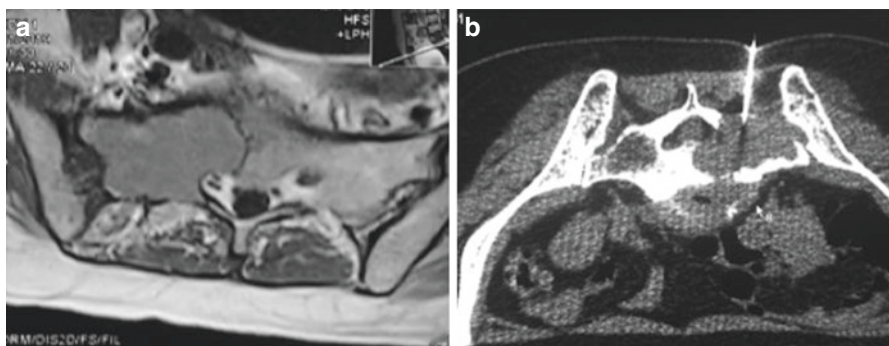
Axial T1 weighted MRI (a) reveals a bone lesion in the right sacral ala. CT-guided fine needle aspiration (b) with the patient in prone position. The needle easily punctures the thin residual enveloping bone along the posterior aspect
